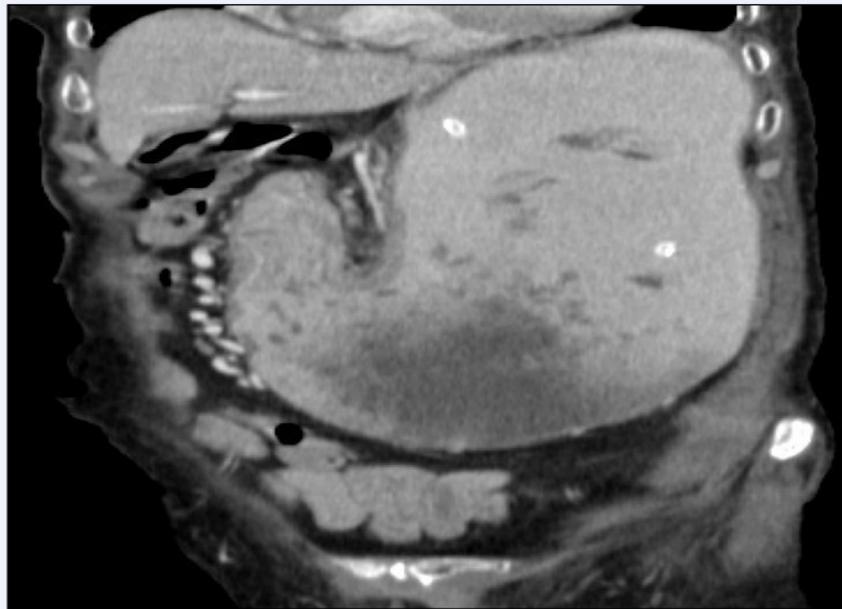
Coronal reformatted abdominal CT shows clear view of the distant areas of stomach
